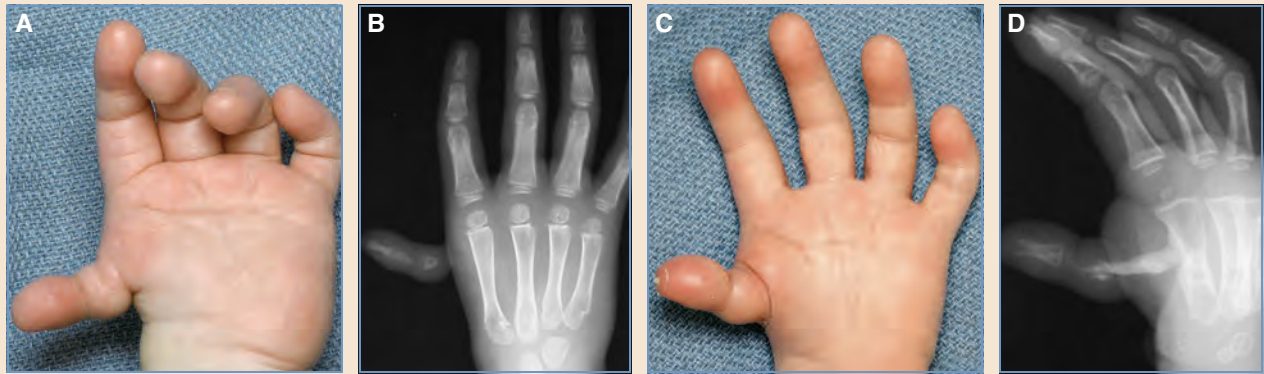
Type IV thumb construction. A and B, The preoperative radiograph and clinical appearance of a type IV thumb in a child whose parents insisted on saving it. C and D, A bridging iliac corticocancellous bone graft was used to stabilize the thumb, which became an immobile post and did not grow commensurately with the child. At 14 years of age, the patient came to our clinic and asked when I would give her a “normal” thumb.
